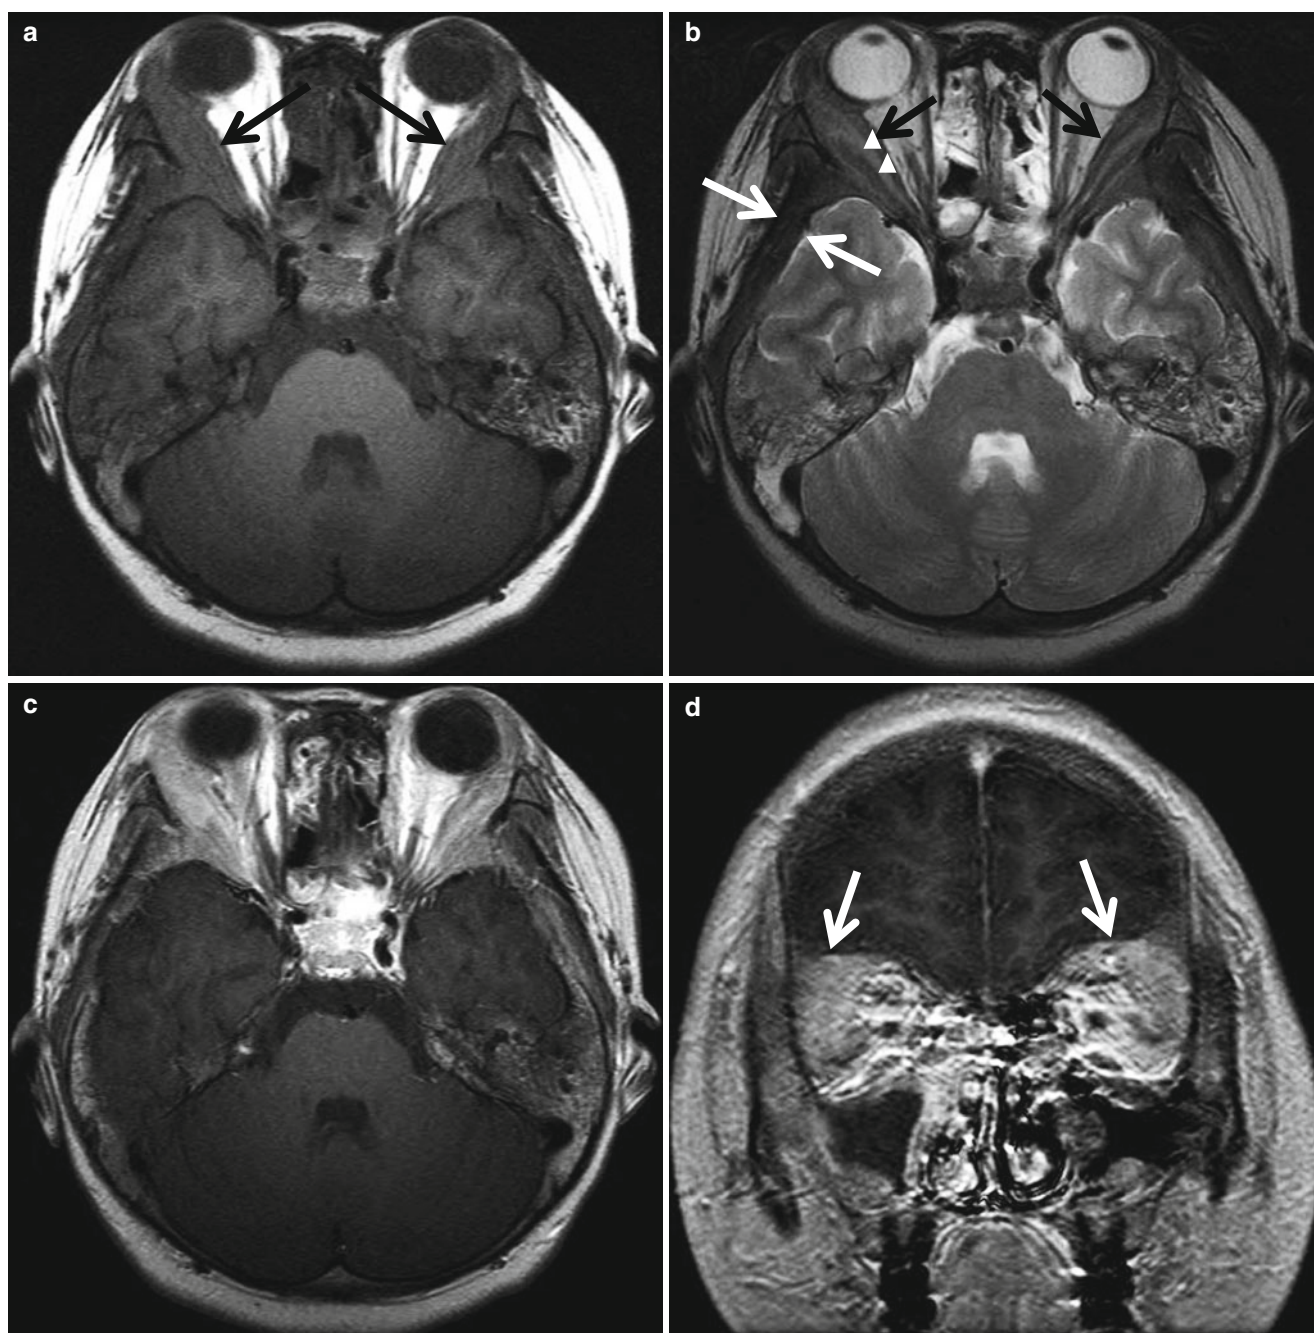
Orbital chloromas in a 12-year-old girl with acute myelogenous leukemia. (a) Axial T1-weighted MR image shows both lateral rectus muscles (*black arrows*) diffusely thickened, with iso-signal intensity relative to muscle. (b) Axial T2-weighted image shows thickened lateral rectus muscles of iso-signal intensity (*black arrows*) and lateral orbit walls of slightly high signal intensity (*arrowheads*). Diploic spaces of both temporal bones are widened (*white arrows*). (c) Contrast-enhanced axial T1-weighted image shows homogeneously
